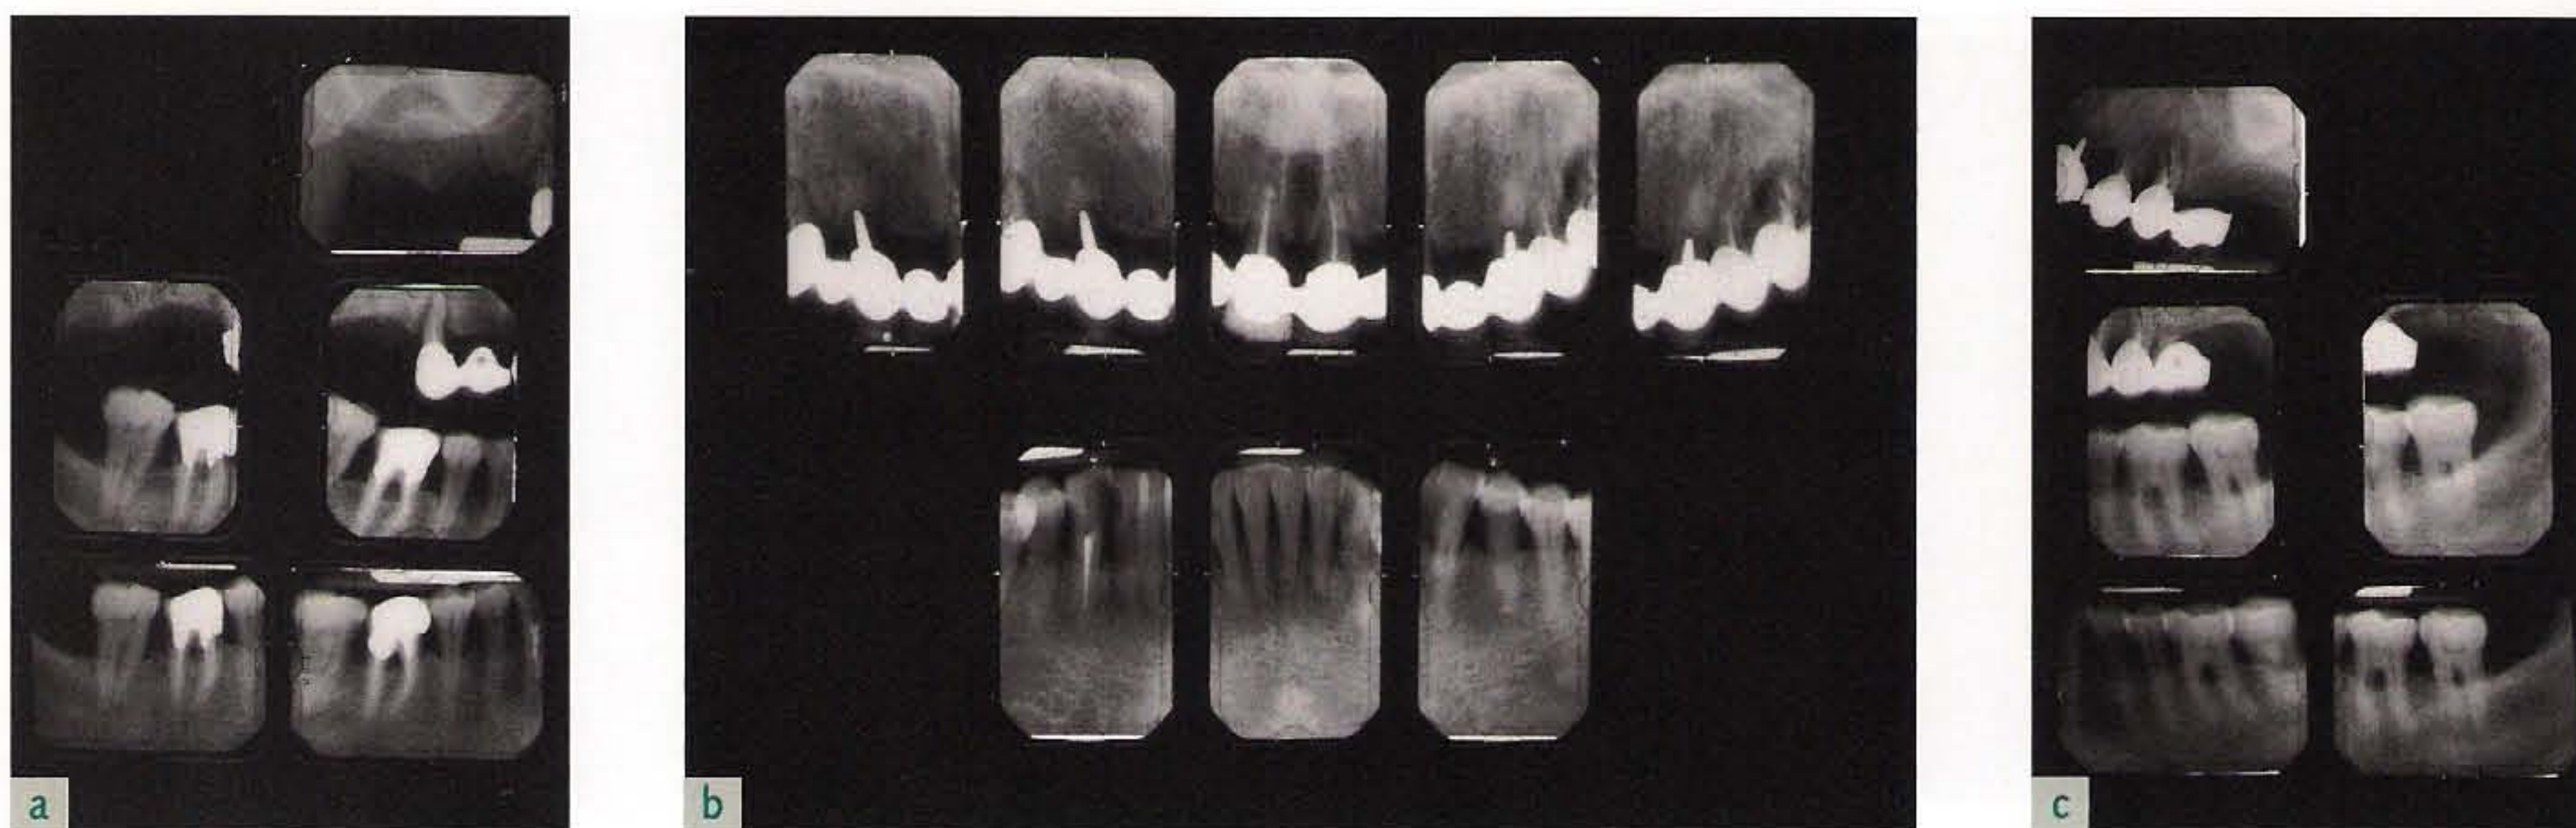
(a to c) Systematic radiographic evaluation of one patient. (Figs 9-148 to 9-176 courtesy of Dr Gaetano Calesini.)
